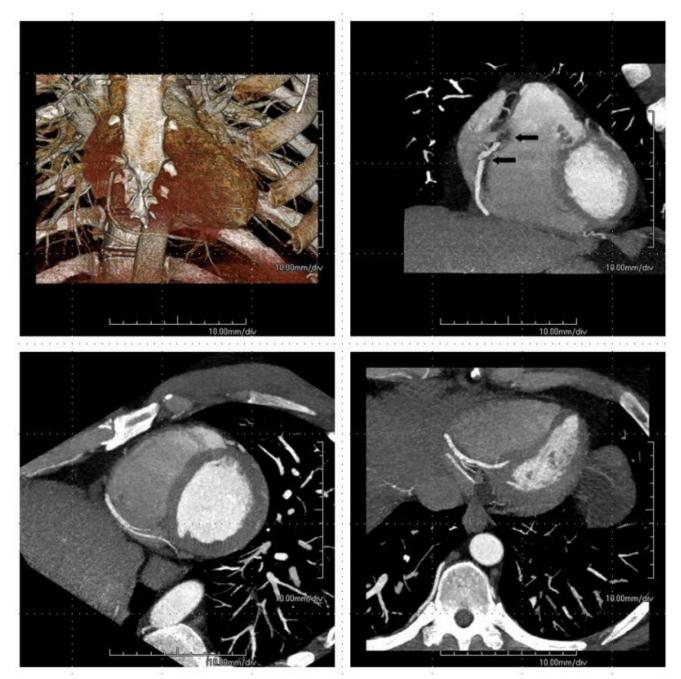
47-year-old male underwent cardiac CT which shows step-stair and banding artifacts. This figure shows VR and three MIP projections similar to Figure 2 after correction of data which involved deleting pseudo-ectopic beats and inserting good data from other parts of the cardiac cycle. Banding artifacts are completely eliminated. Residual step-stair artifacts indicated by black horizontal arrows are seen in proximal RCA regions.
